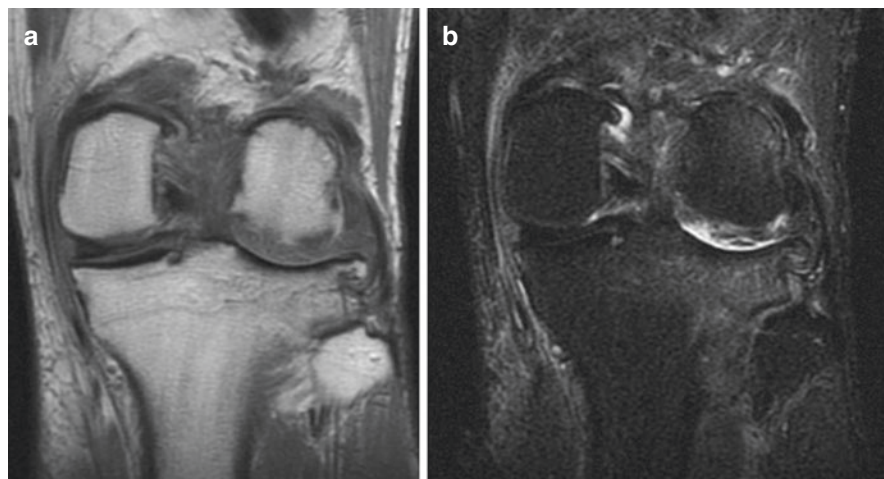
Coronal T1 (a) and STIR (b) knee MR images depicting high-grade lateral femoral condyle and tibial plateau chondropathy
